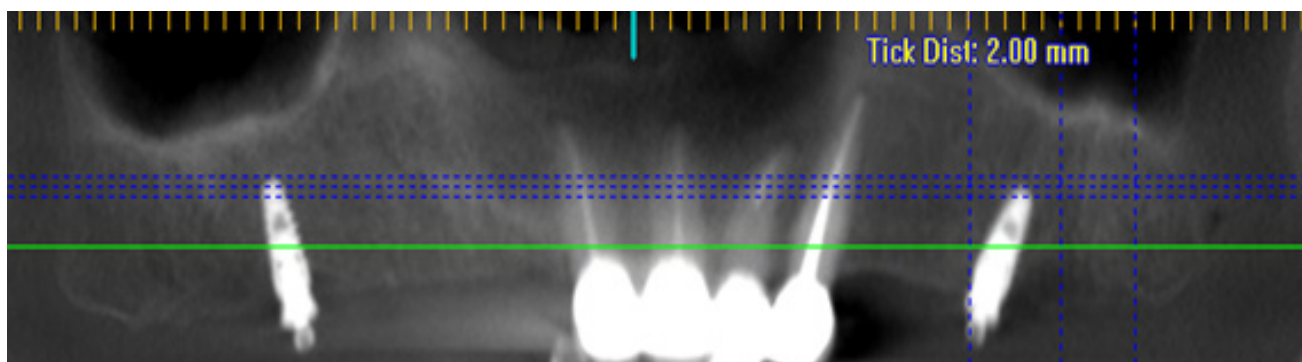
Cone beam computed tomography at follow up appointments after implant loading.
